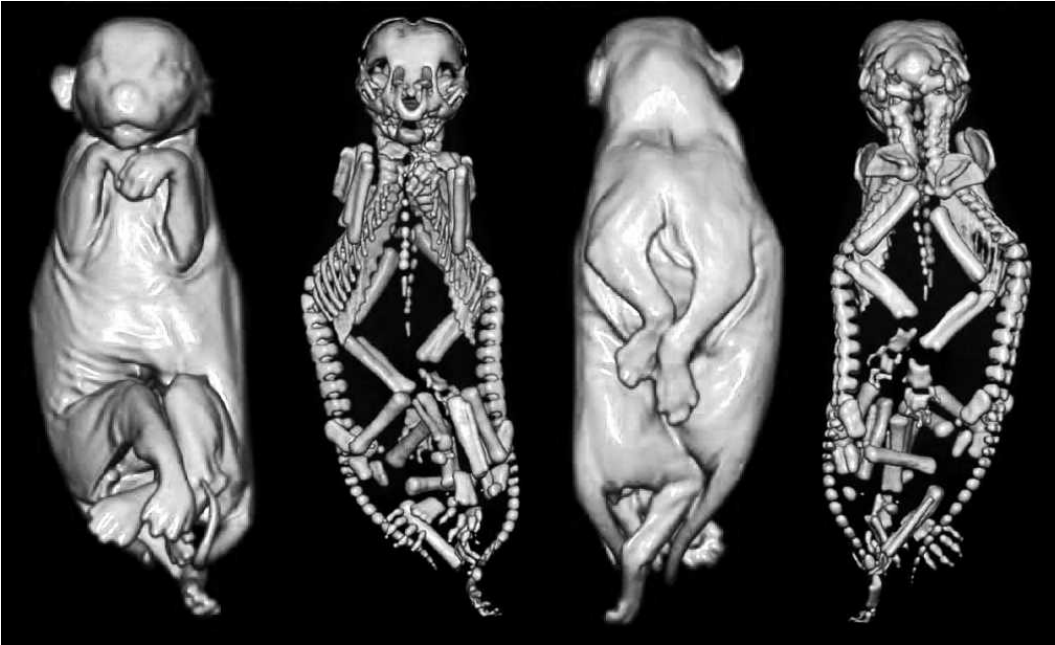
Prionailurus bengalensis* cephalopagus conjoined twins (NMR 9990-00002574). Images from CT scanning. Posterior and anterior view.
